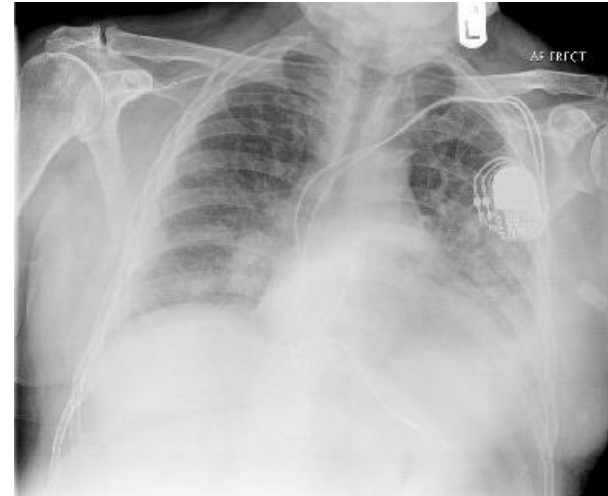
X-ray of patient with LVF showing showing plethoric (blood vessels engorged) lung fields due to pulmonary oedema (also a pacemaker)
